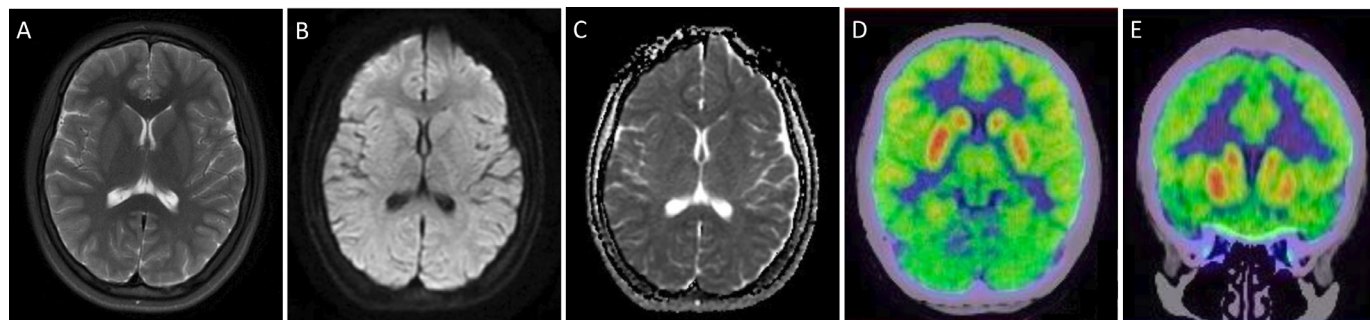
Representative brain MRI and fluorodeoxyglucose positron emission tomography (FDG-PET) images in a patient with antiphospholipid antibody-related chorea. A teenage patient with triple-positive antiphospholipid antibodies presented with bilateral chorea, more dominant on the left side. The brain MRI (A–C) was normal, but FDG-PET-CT (D–E) revealed significant bilateral striatal hypermetabolism, more dominant on the right side.
